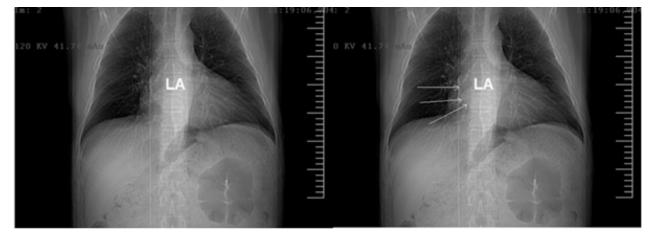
Chest X-ray of the thorax. PA view. "Double density" sign given by a mild dilation of the left atrium.
